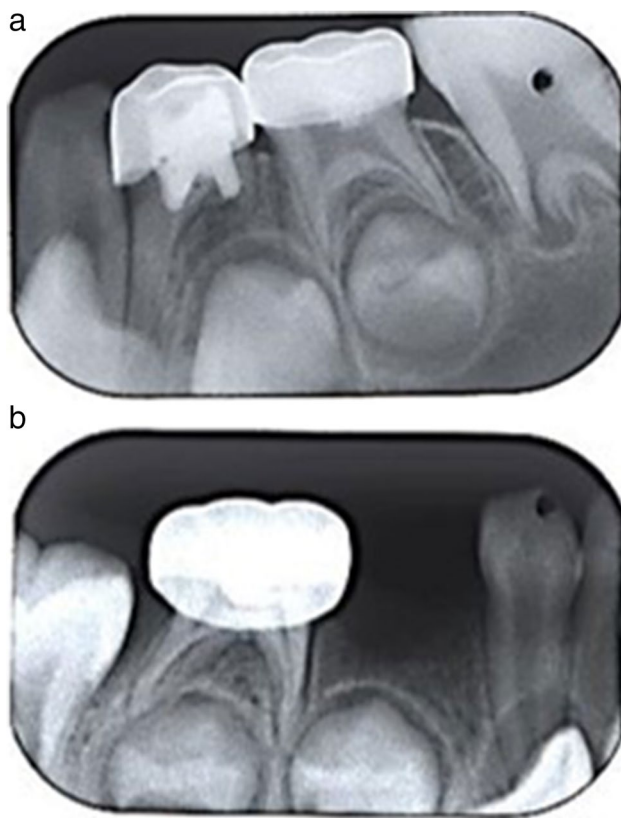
The 18-month periapical radiographs in two patients after partial pulpotomy with MTA. A A successful result in tooth 75; B a failed outcome in tooth 75, displayed by widened PDL space and periapical and furcal radiolucencies
